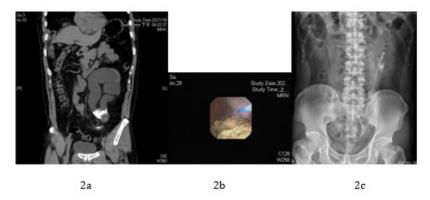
The computed tomography after the first time of retrograde intrarenal surgery. Residual stone with size measured as 3.0\*2.0cm was stuck at the Y junction of bifid ureter.
